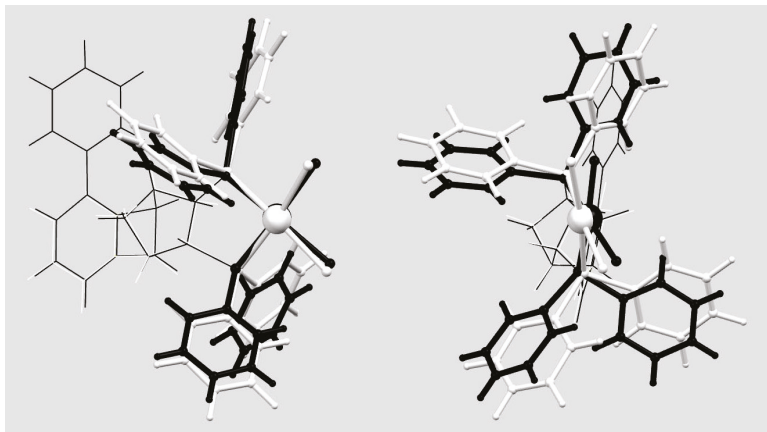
The structural overlay of the molecules of the coordination compounds $[\text{Pd}(\mathbf{6q})\text{Cl}_2]^{xray}$ and $[\text{Pd}(\mathbf{6q})\text{Cl}_2]^{calc}$: front and side views. Black: measured X-ray structure $[\text{Pd}(\mathbf{6q})\text{Cl}_2]^{xray}$, white: calculated geometry of $[\text{Pd}(\mathbf{6q})\text{Cl}_2]^{calc}$. The fragments that match are marked with thin lines.
